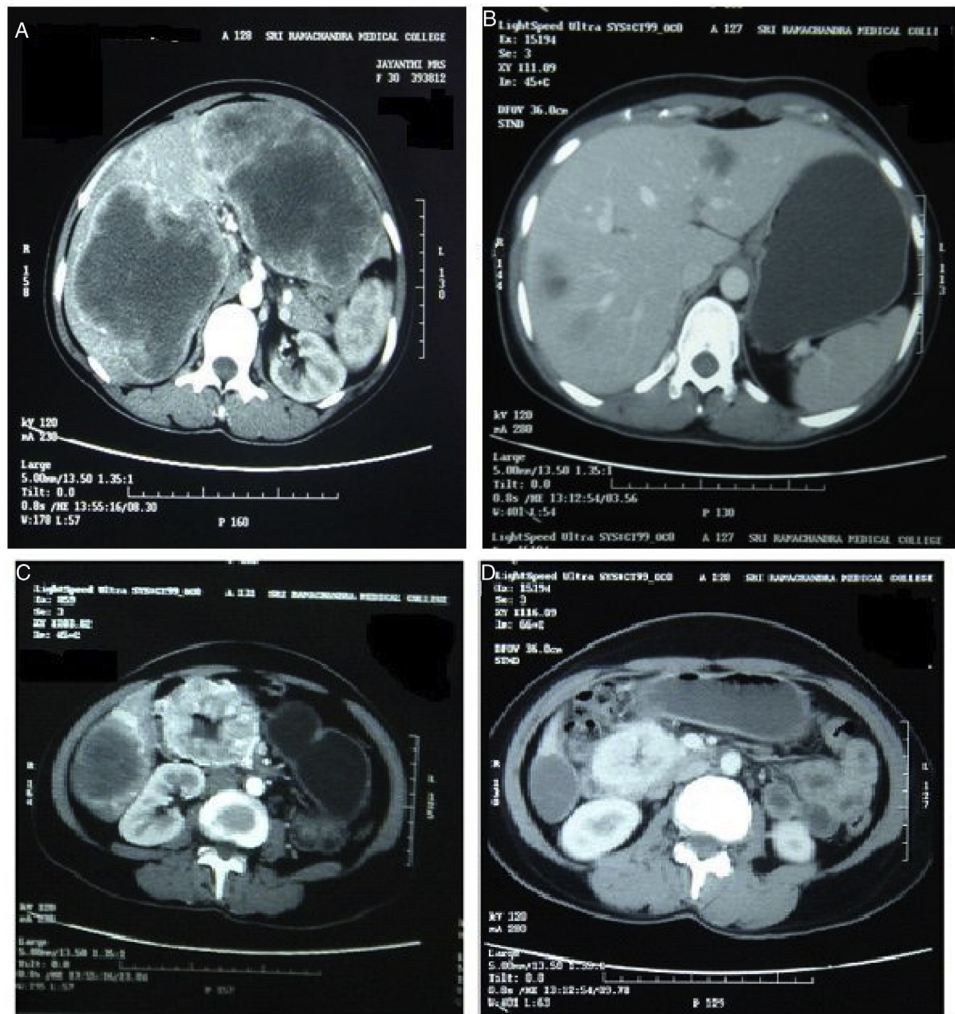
(A) CT scan showing liver metastasis. (B) Dramatic response to imatinib mesylate with complete disappearance of liver metastasis. (C and D) CT showing unresponsive primary tumour in the duodenum.
